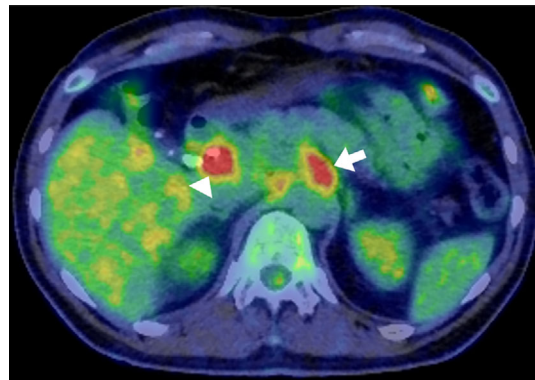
PET-CT (July, 20XX). Accumulation with an SUVmax of 5.0→6.6 confined to the common bile duct (arrowhead) was observed, along with accumulation with an SUVmax of 4.1→4.9 (arrowhead) against the soft tissue mass surrounding the celiac artery.
